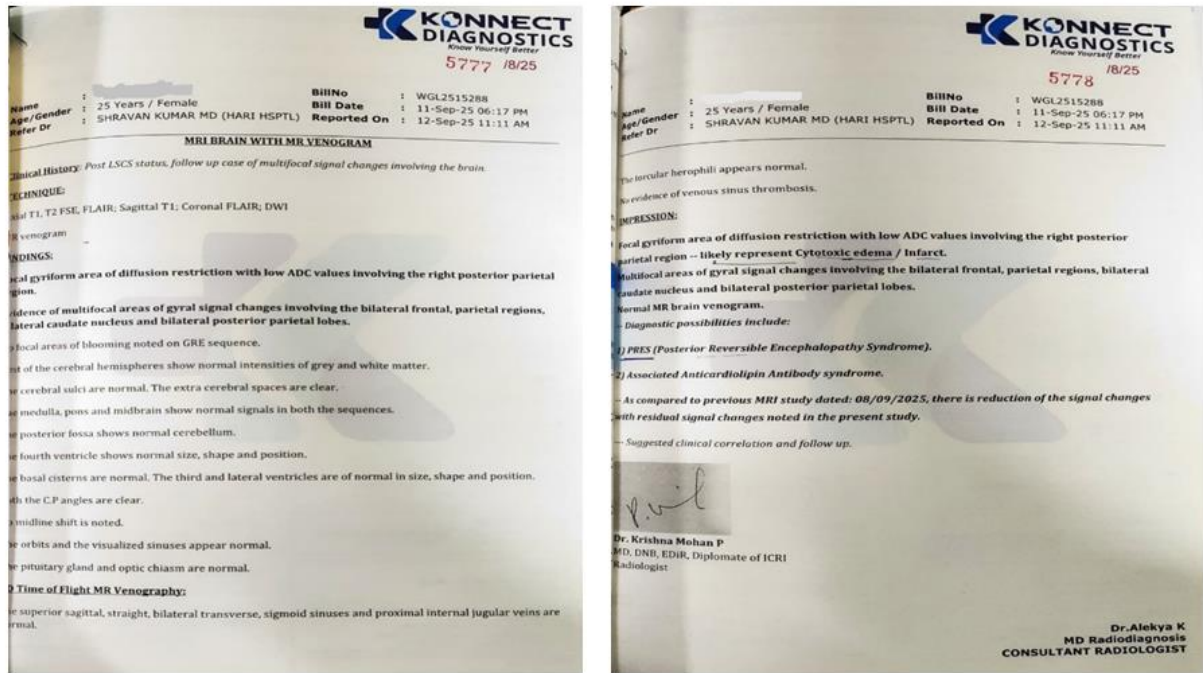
Evidence of the MRI brain with MR Venogram.
